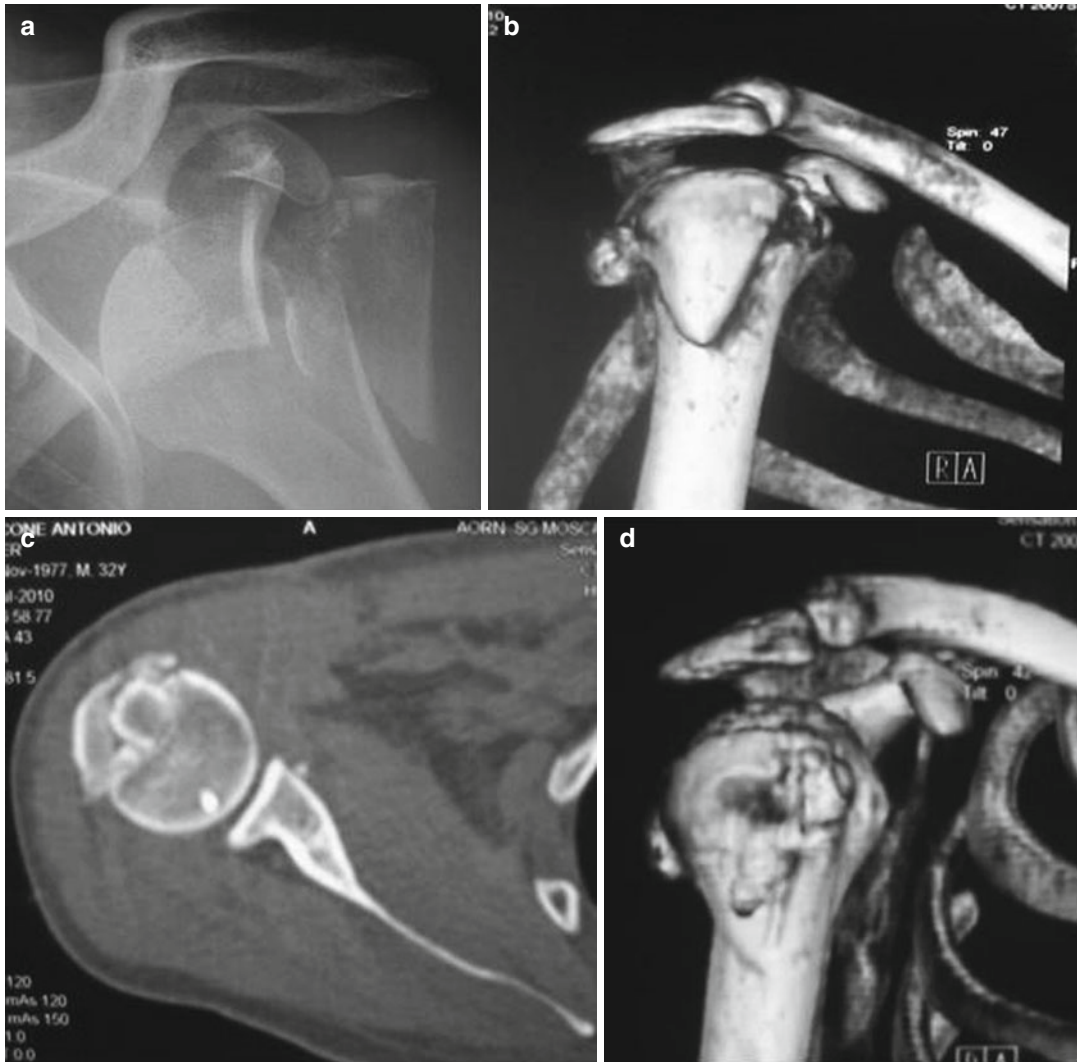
Complex three-part fracture-dislocation with bone loss between the lesser and greater tuberosities. (a) Anteroposterior X-ray showing the anterior dislocation of the head and the fracture of the lesser and greater tuberosities. (b) 3D CT scan reconstruction showing displacement of fragments after reduction. (c) Axial
